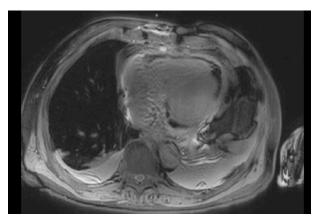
MRI of the heart revealing pericardial effusion and a normal cardiac musculature.
